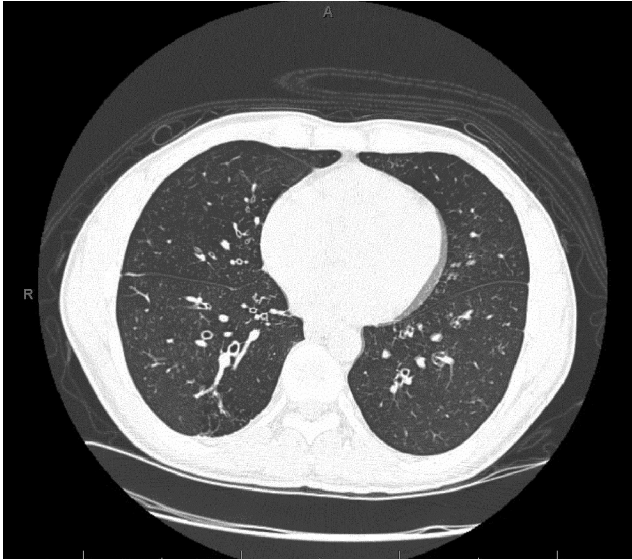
Computed tomography of the chest, revealing centrilobular densities.
